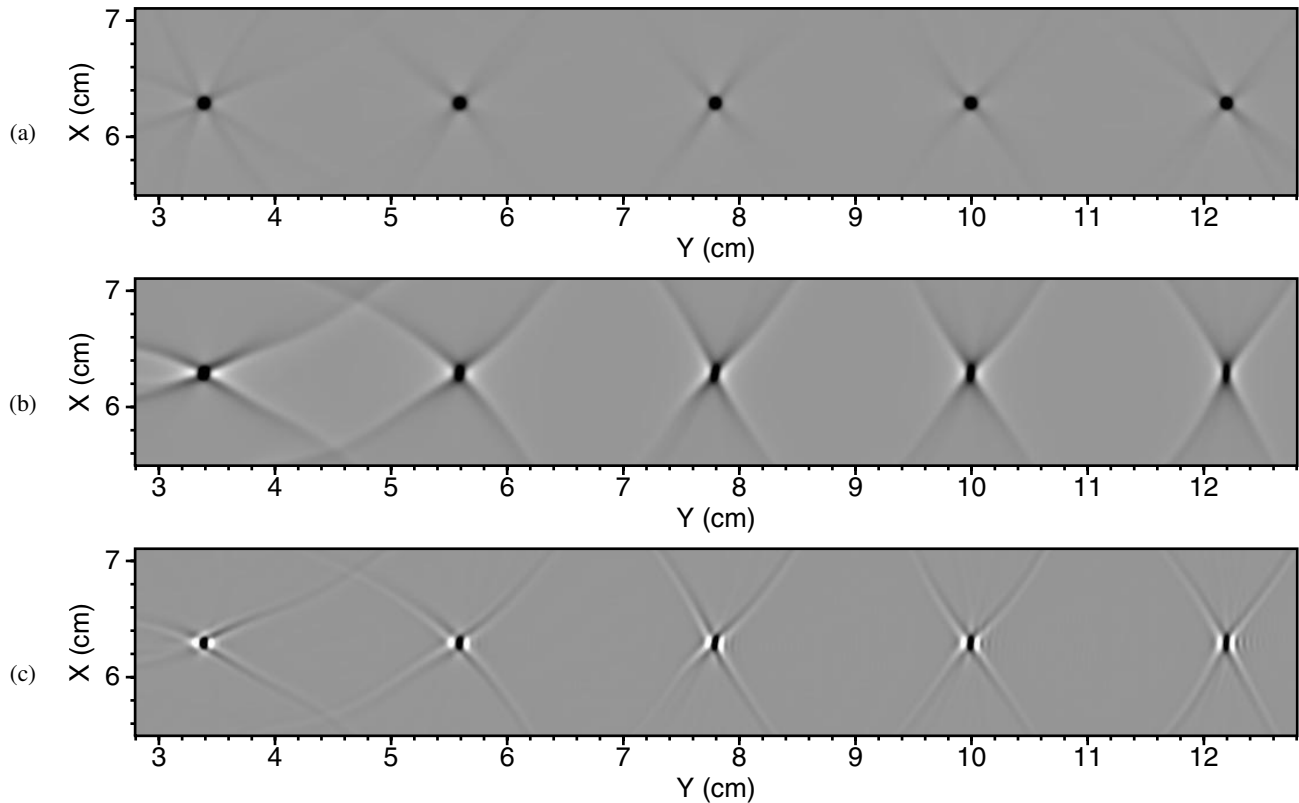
Images in (a) and (b) are imaging results of five point sources obtained by backpropagating time-reversed signals using a finite-difference two-way wave-equation method. (a) is the result when using recorded ultrasonic signals at all boundaries of the breast model, and (b) is that when using only ultrasonic signal at the top boundary of the breast model. (c) is the imaging result yielded using a solution of one-way wave equation for backpropagation of time-reversed data at the top boundary of the breast model.
